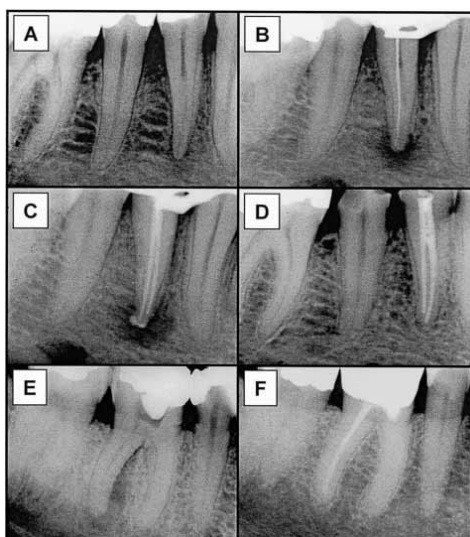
Appearance of apical periodontitis and features of healing. In (A) through (D), the mandibular first premolar shows features of lamina dura disruption and bone structural changes in (A); 2 weeks later, there is a clear radiolucency confirming an established lesion (B); the root filling 1 week later shows a surplus (C); at the 3-year recall, healing is complete except for some discontinuities in the lamina dura and minor structural disorganization of the apical bone. The distal root of the mandibular first molar in (E) shows chronic apical periodontitis with signs of exacerbation; 24 years after endodontic treatment, there is complete restitution of the periapical bone. Courtesy Nair et. al
